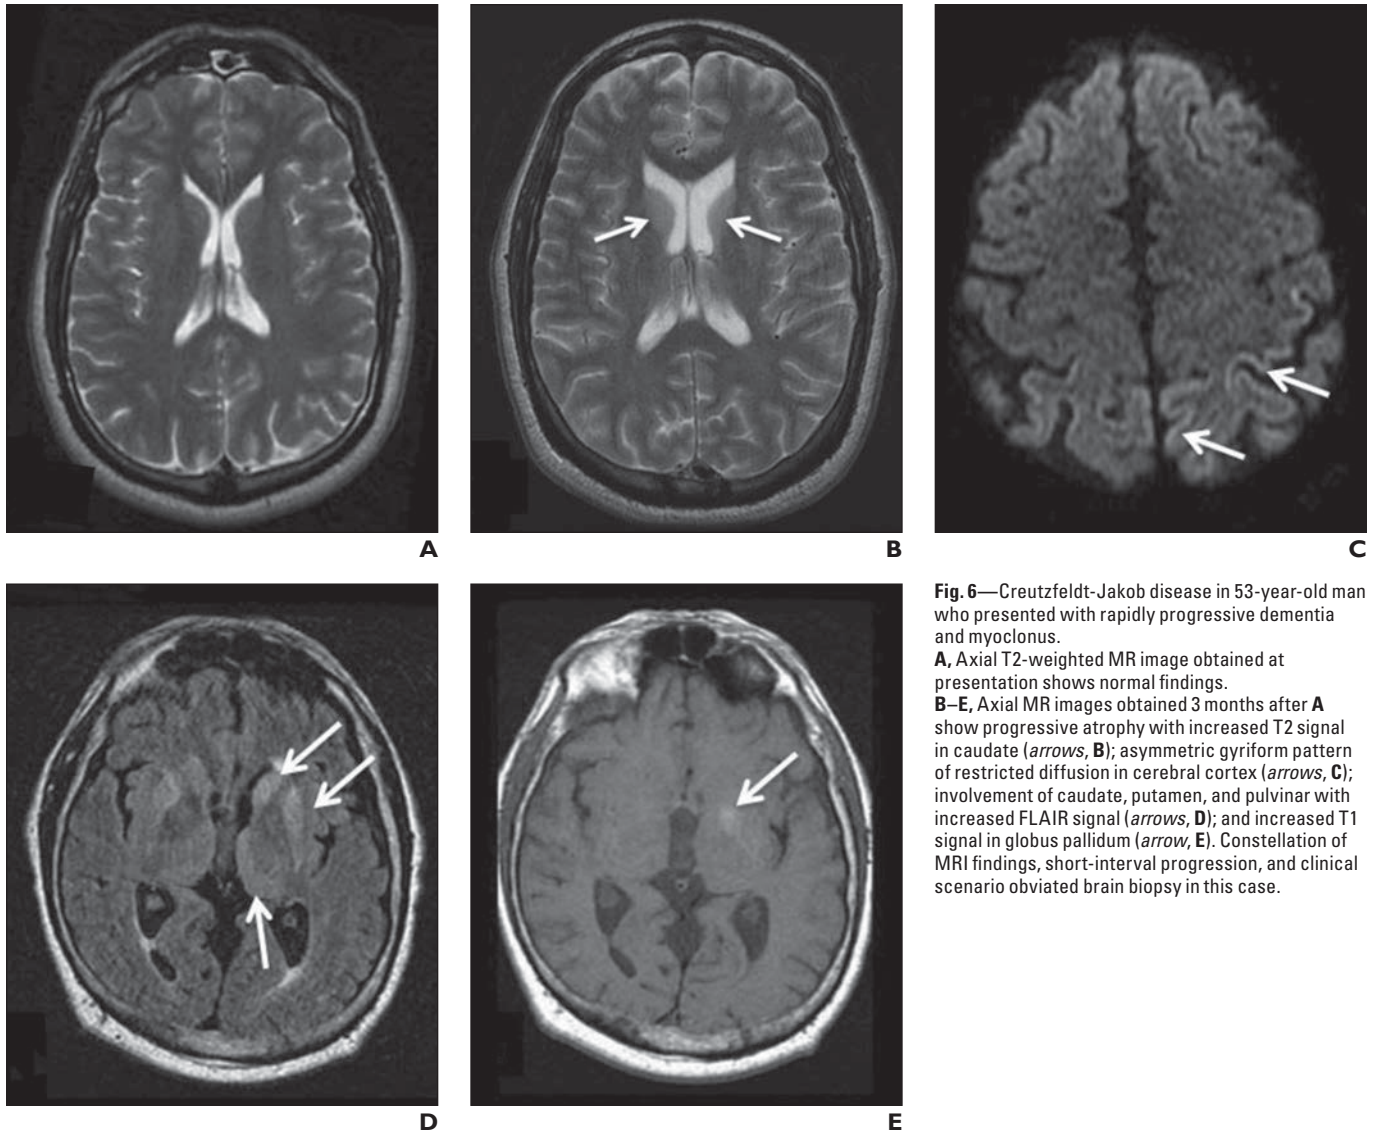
Creutzfeldt-Jakob disease in 53-year-old man who presented with rapidly progressive dementia and myoclonus. A, Axial T2-weighted MR image obtained at presentation shows normal findings. B–E, Axial MR images obtained 3 months after A show progressive atrophy with increased T2 signal in caudate (*arrows*, B); asymmetric gyriform pattern of restricted diffusion in cerebral cortex (*arrows*, C); involvement of caudate, putamen, and pulvinar with increased FLAIR signal (*arrows*, D); and increased T1 signal in globus pallidum (*arrow*, E). Constellation of MRI findings, short-interval progression, and clinical scenario obviated brain biopsy in this case.
